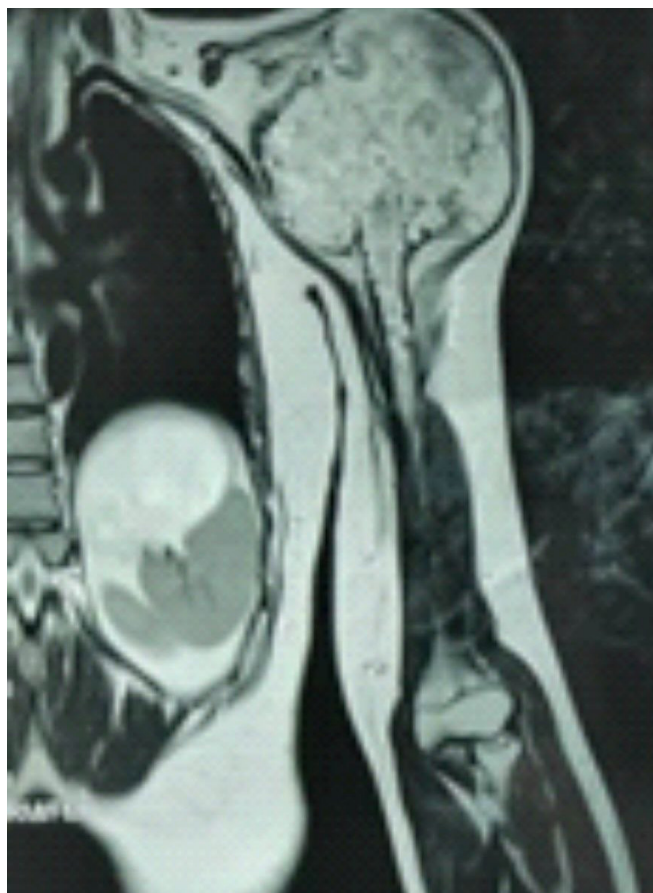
MRI shows heterogeneity large volume low grade chondrosarcoma tumour on proximal left humerus.
